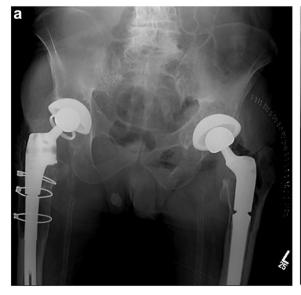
(a) Immediate postoperative anterior-posterior (AP) pelvis and (b) AP left hip radiographs demonstrating the patient's left revision total hip arthroplasty with noted periacetabular bone grafting.
